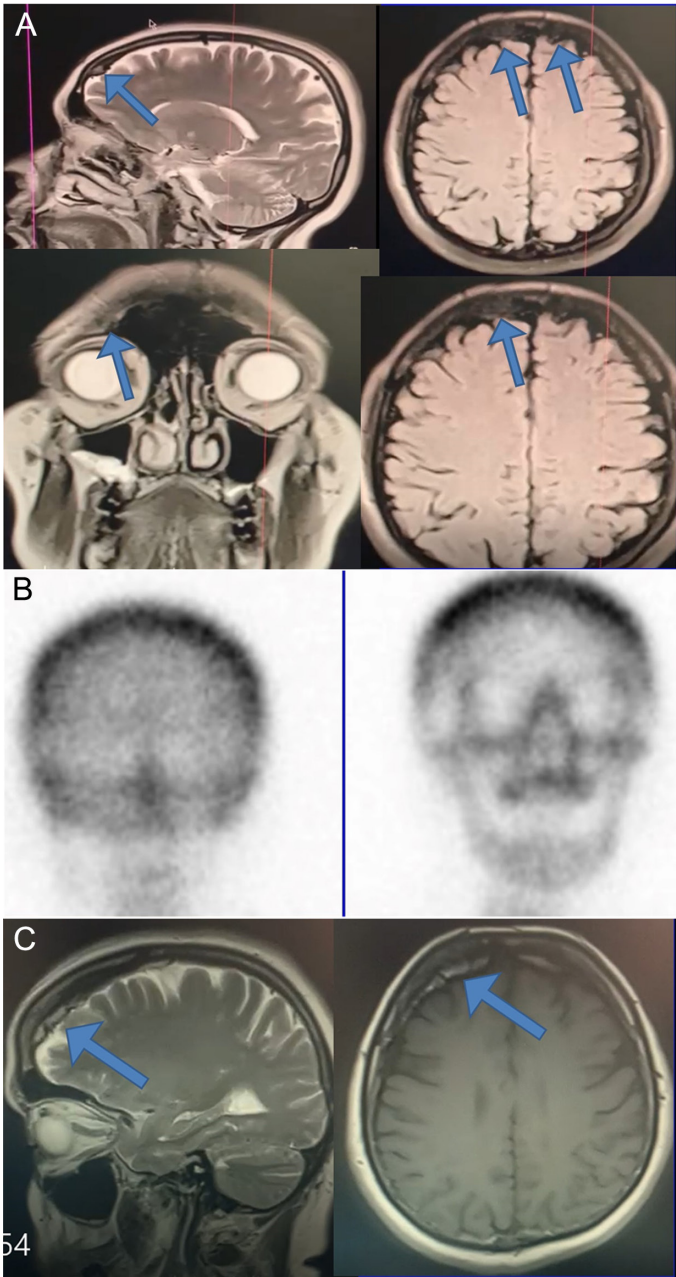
(A) HFI is demonstrated (arrow) on cranial MRI of a 37-year-old obese female patient presented with headache. (B) HFI is demonstrated on bone scan of a 52-year-old female patient with type 2 diabetes, obesity, hypertension, and adrenal Cushing syndrome (adrenalectomized) who was evaluated for unexplained alkaline phosphatase elevation. (C) HFI is demonstrated (arrow) on cranial MRI of a 65-year-old postmenopausal woman. HFI, hyperostosis frontalis; interna MRI, magnetic resonance imaging.
